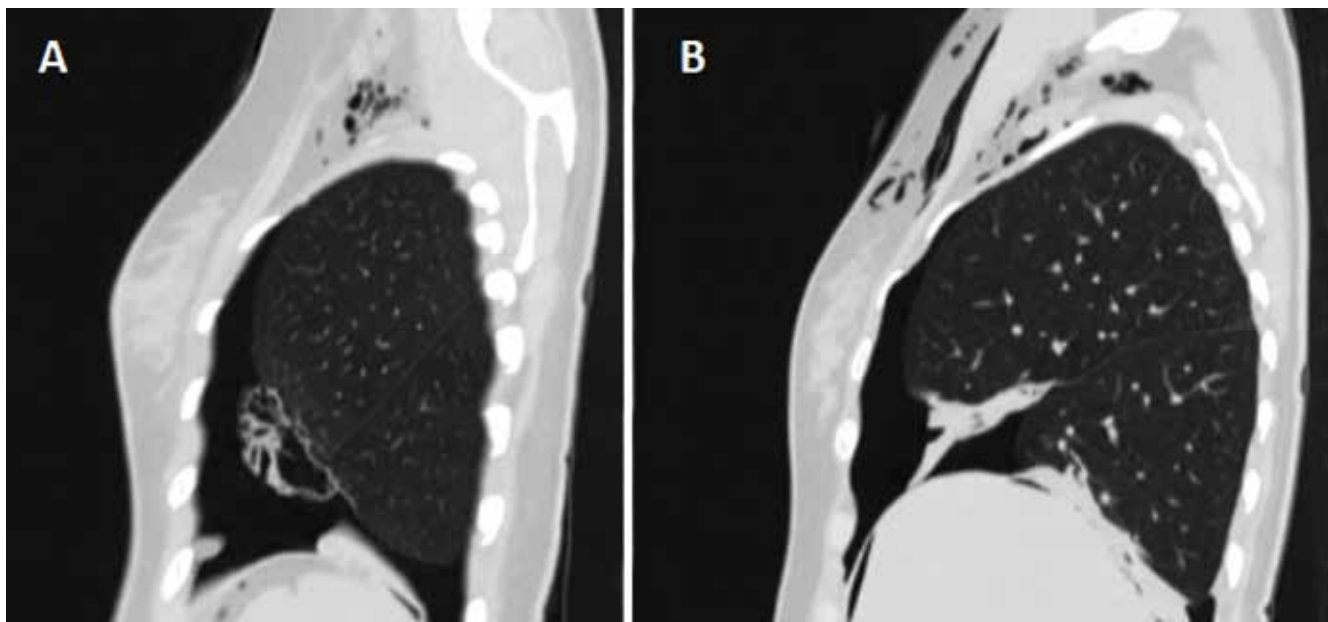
Chest computed tomography sagittal section of the left lung (A) and right lung (B).
